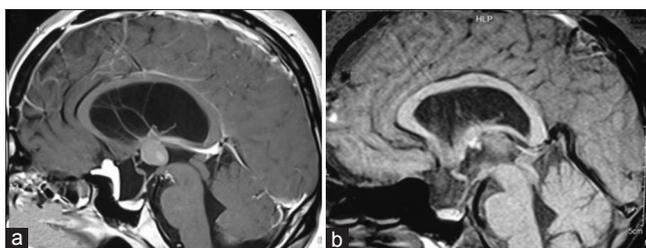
Sagittal sections of contrast-enhanced magnetic resonance images of brain showing cystic lesion in the suprasellar area with small solid part anteriorly. Cyst displaced the pituitary stalk posteriorly. Pituitary gland is seen compressed in the sella. Colloid cyst of the third ventricle is evident with mild ventriculomegaly (a). Post-operative scans (48 hrs) scans showed complete excision of dermoid and colloid cyst with decreased mass effect on the optic chiasm (b)
